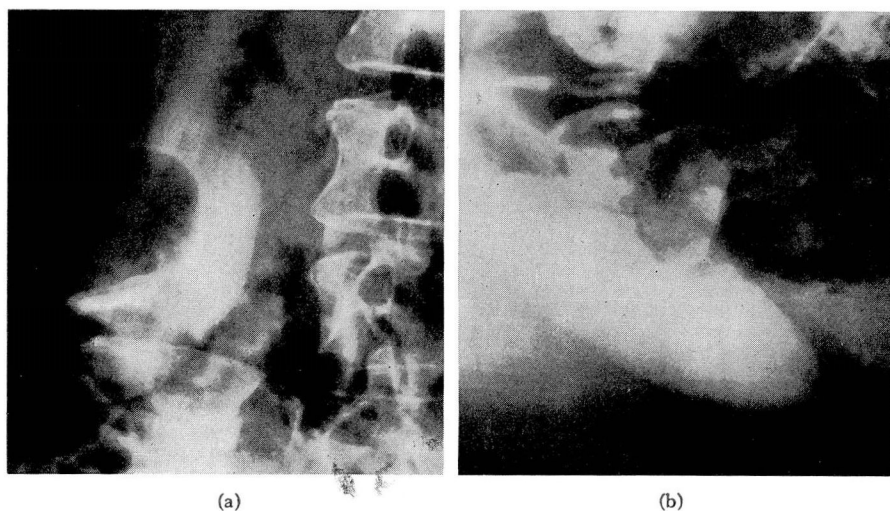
Normal gallbladder. (a) Posteroanterior prone roentgenogram with gallbladder obscured by intestinal gas, fecal matter, and the right iliac crest. (b) Posteroanterior lateral decubitus roentgenogram showing a normal gallbladder lying unobscured in right flank.
